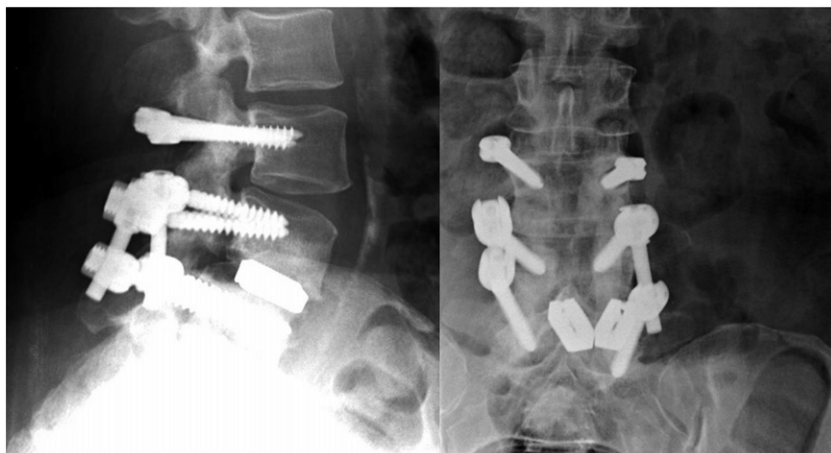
Lateral and anteroposterior radiographs at 4 months postoperatively, showing more pronounced lucency and sclerotic margin surrounding the left L3 screw.
